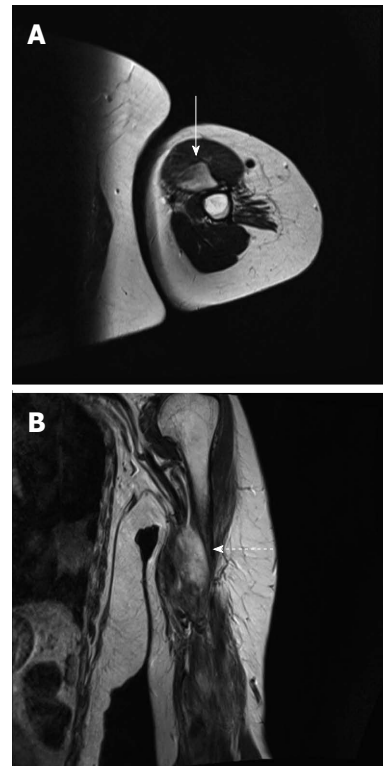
Magnetic resonance imaging of the left arm. A: Axial T2-weighted image showing a huge, ill-defined, high-signal-intensity mass (solid arrow); B: Coronal T2-weighted image showing a high-signal-intensity mass (dotted arrow).
